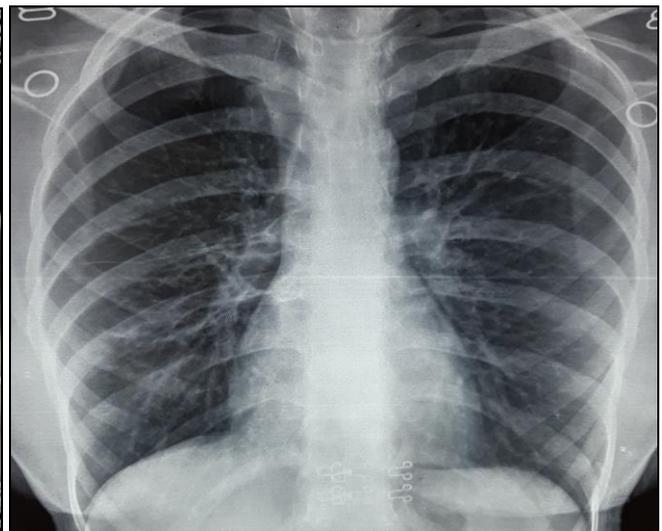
Contrast enhanced CT scan of the paranasal sinus (A) showed sinonasal polyposis with hypertrophy of right inferior nasal turbinate. Chest radiograph (B) obtained one month later demonstrated significant resolution of the right upper lobe mass lesion.
